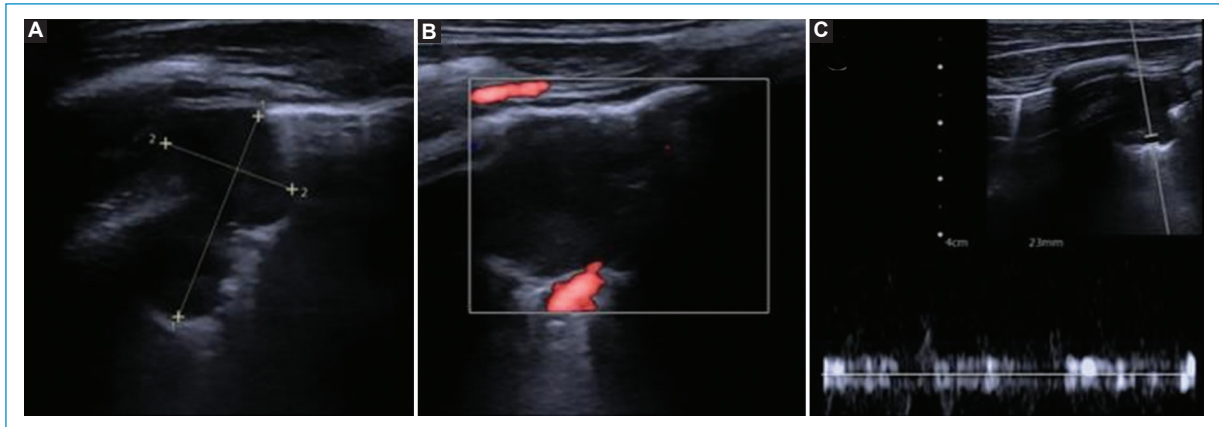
A-C: ultrasound of the lung nodular structure, confirming the vascular nature of the lesion.
